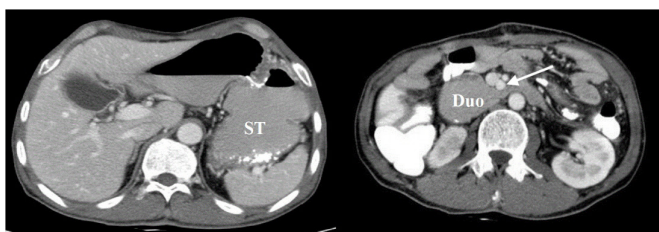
CT scan demonstrated a moderately dilated stomach and second part of the duodenum, and compression by the superior mesenteric artery (arrow). The aortomesenteric distance was measured at 7 mm.
